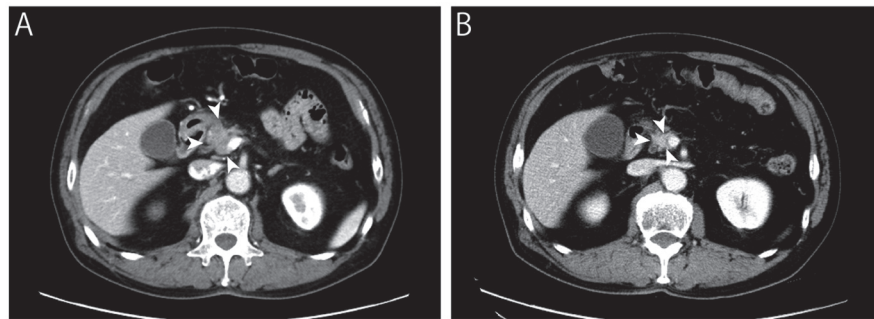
Case 2: Contrast-enhanced CT findings.
